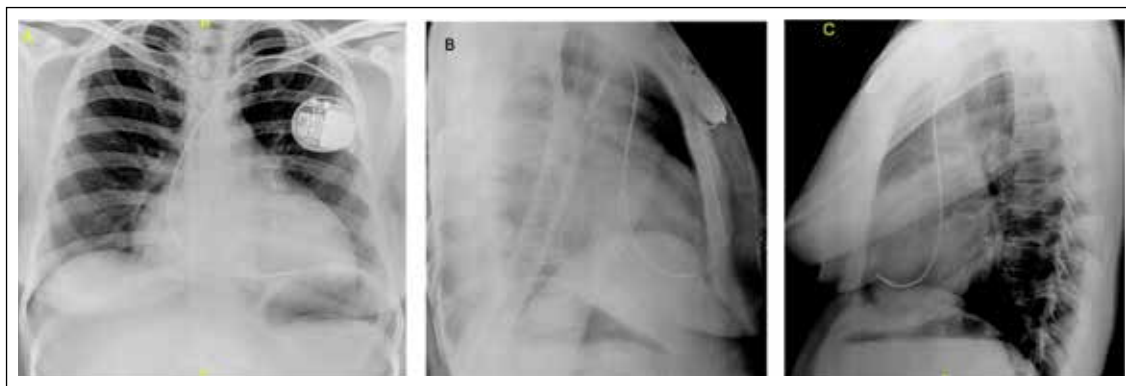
Another case of CHB with single chamber pacemaker insitu, lead position both in frontal (A), right (B) and left lateral (C) chest radiographs.
